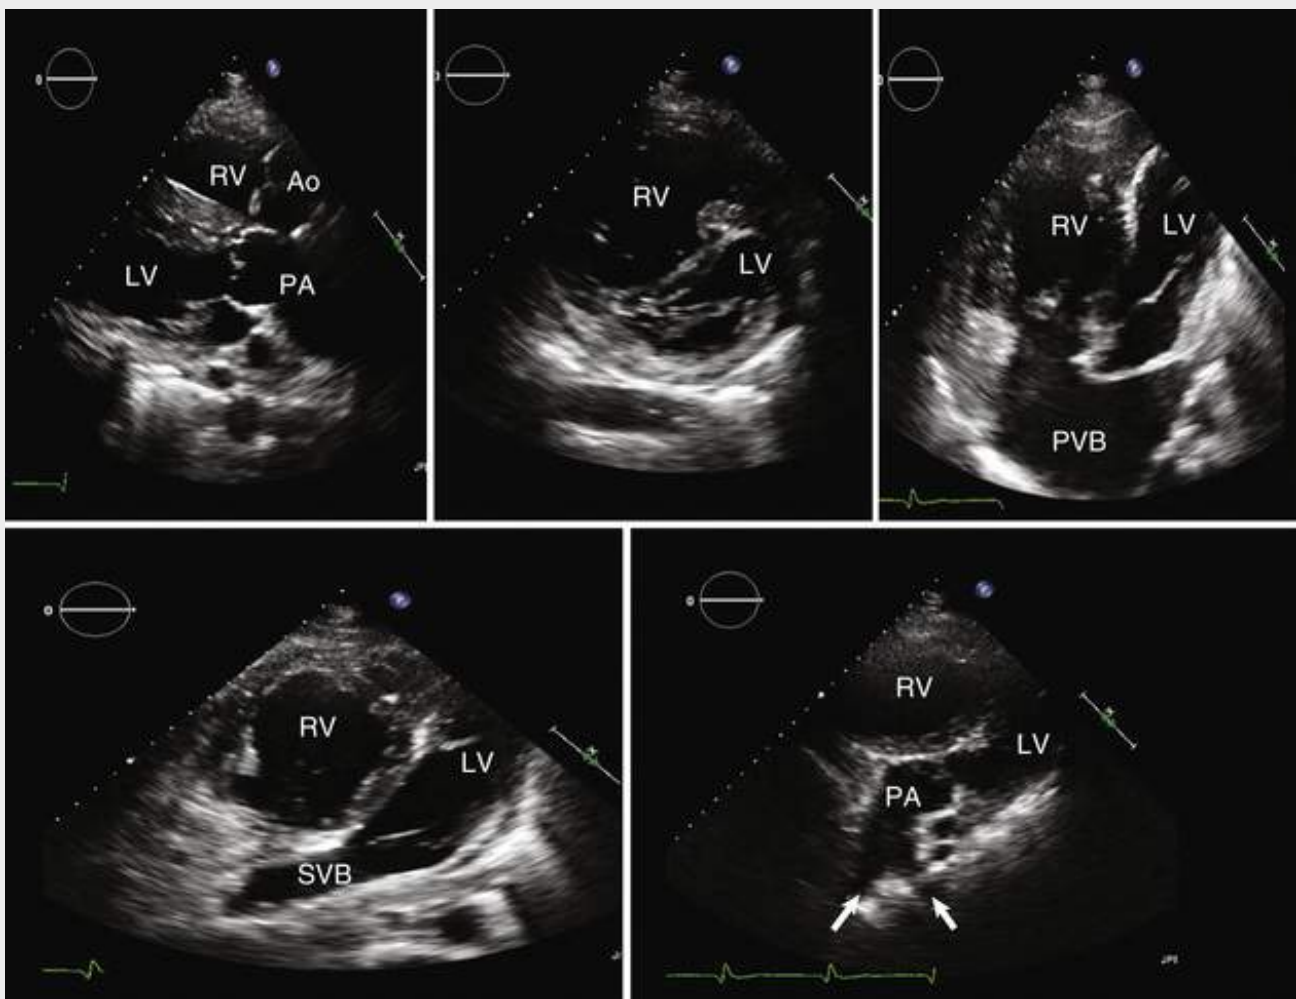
D-Transposition of the great arteries after Mustard baffle surgery. Top left, Parasternal long-axis view showing parallel orientation of the aorta (Ao) and pulmonary artery (PA). The aorta is anterior. Top middle, Parasternal short-axis view showing septal inversion reflecting the fact that the right ventricle (RV) is the systemic ventricle. Top right, Apical four-chamber view showing the pulmonary venous baffle (PVB), which directs pulmonary venous flow across the tricuspid valve into the RV. Bottom left, The four-chamber view has been angulated to demonstrate the systemic venous baffle (SVB), which directs systemic venous return across the mitral valve into the left ventricle (LV). Note the right ventricular hypertrophy and enlargement. Bottom right, The four-chamber view is angulated anteriorly to demonstrate the connection between the LV and PA. Arrows point to the PA bifurcation.
